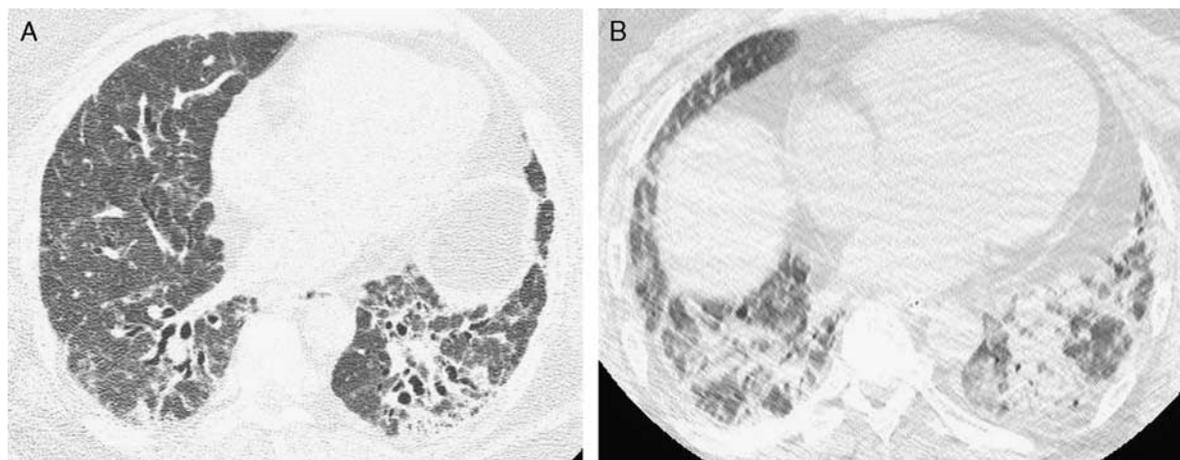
A and B, Acute exacerbation. Baseline HRCT (A) shows reticulation and traction bronchiectasis in a patient with chronic HP. After the development of acute symptoms (B), a repeat HRCT shows new extensive bilateral GGO and consolidation compatible with an acute exacerbation.
